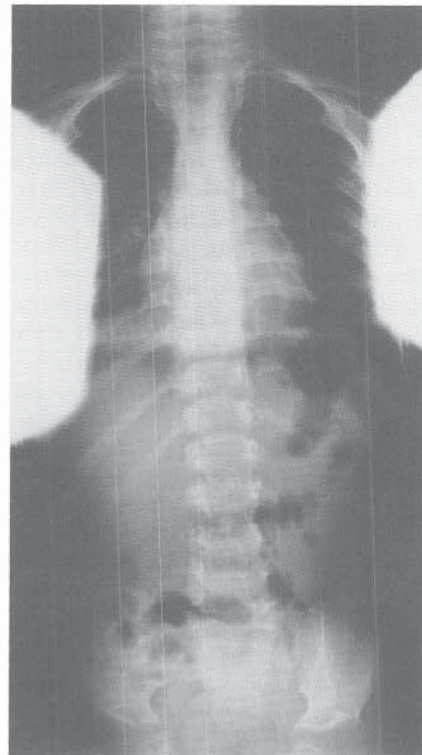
PA radiograph in pseudoachondroplasia showing normal interpedicular distance in the lumbar spine. In achondroplasia, by contrast, there is progressive narrowing of the lumbar interpedicular distance.
